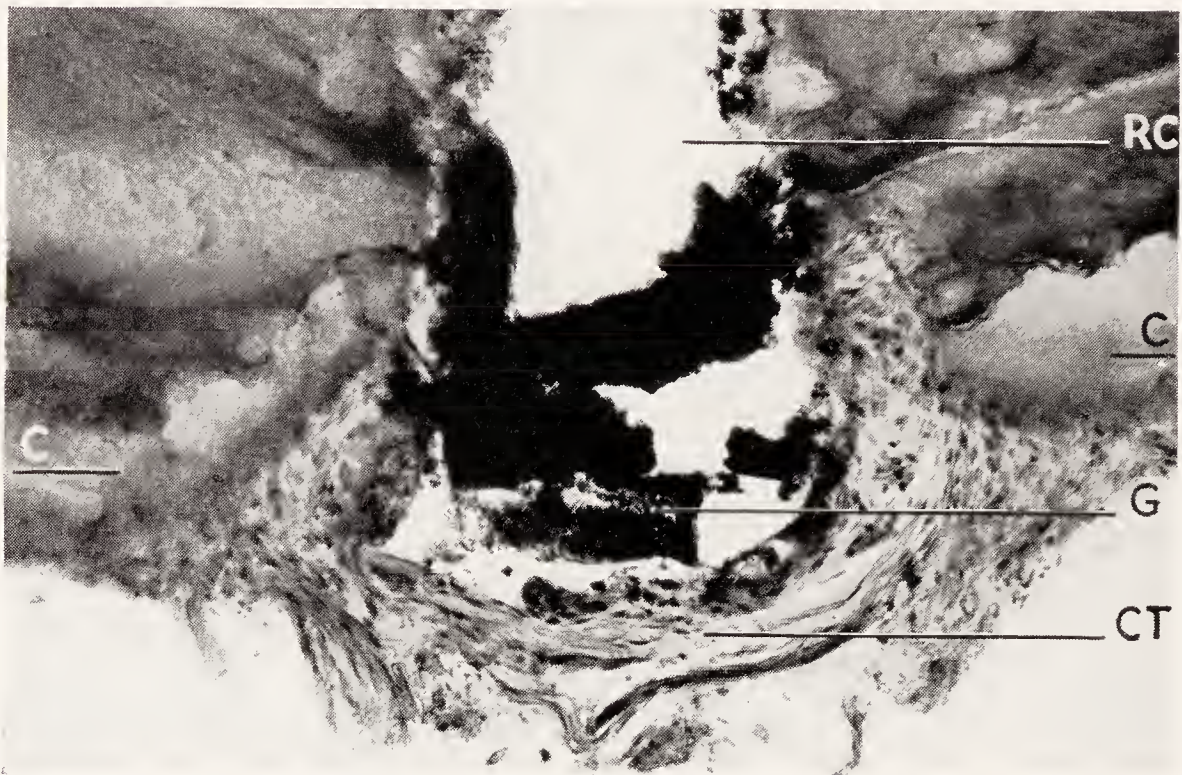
Root end with slightly overfilled root canal. Lower bicuspid. *RC*, root canal; *G*, guttapercha; *CT*, connective tissue capsule surrounding the end of the root canal filling; *C*, deposits of new cementum on either side of the root canal.
